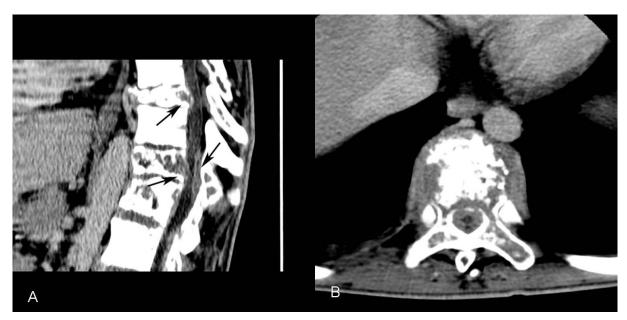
Contrast-enhanced CT scan of spine with sagittal (A) and axial (B) reformatted (soft window) images through thoracic vertebrea show vertebral involvement and compression of the cord (arrows).
